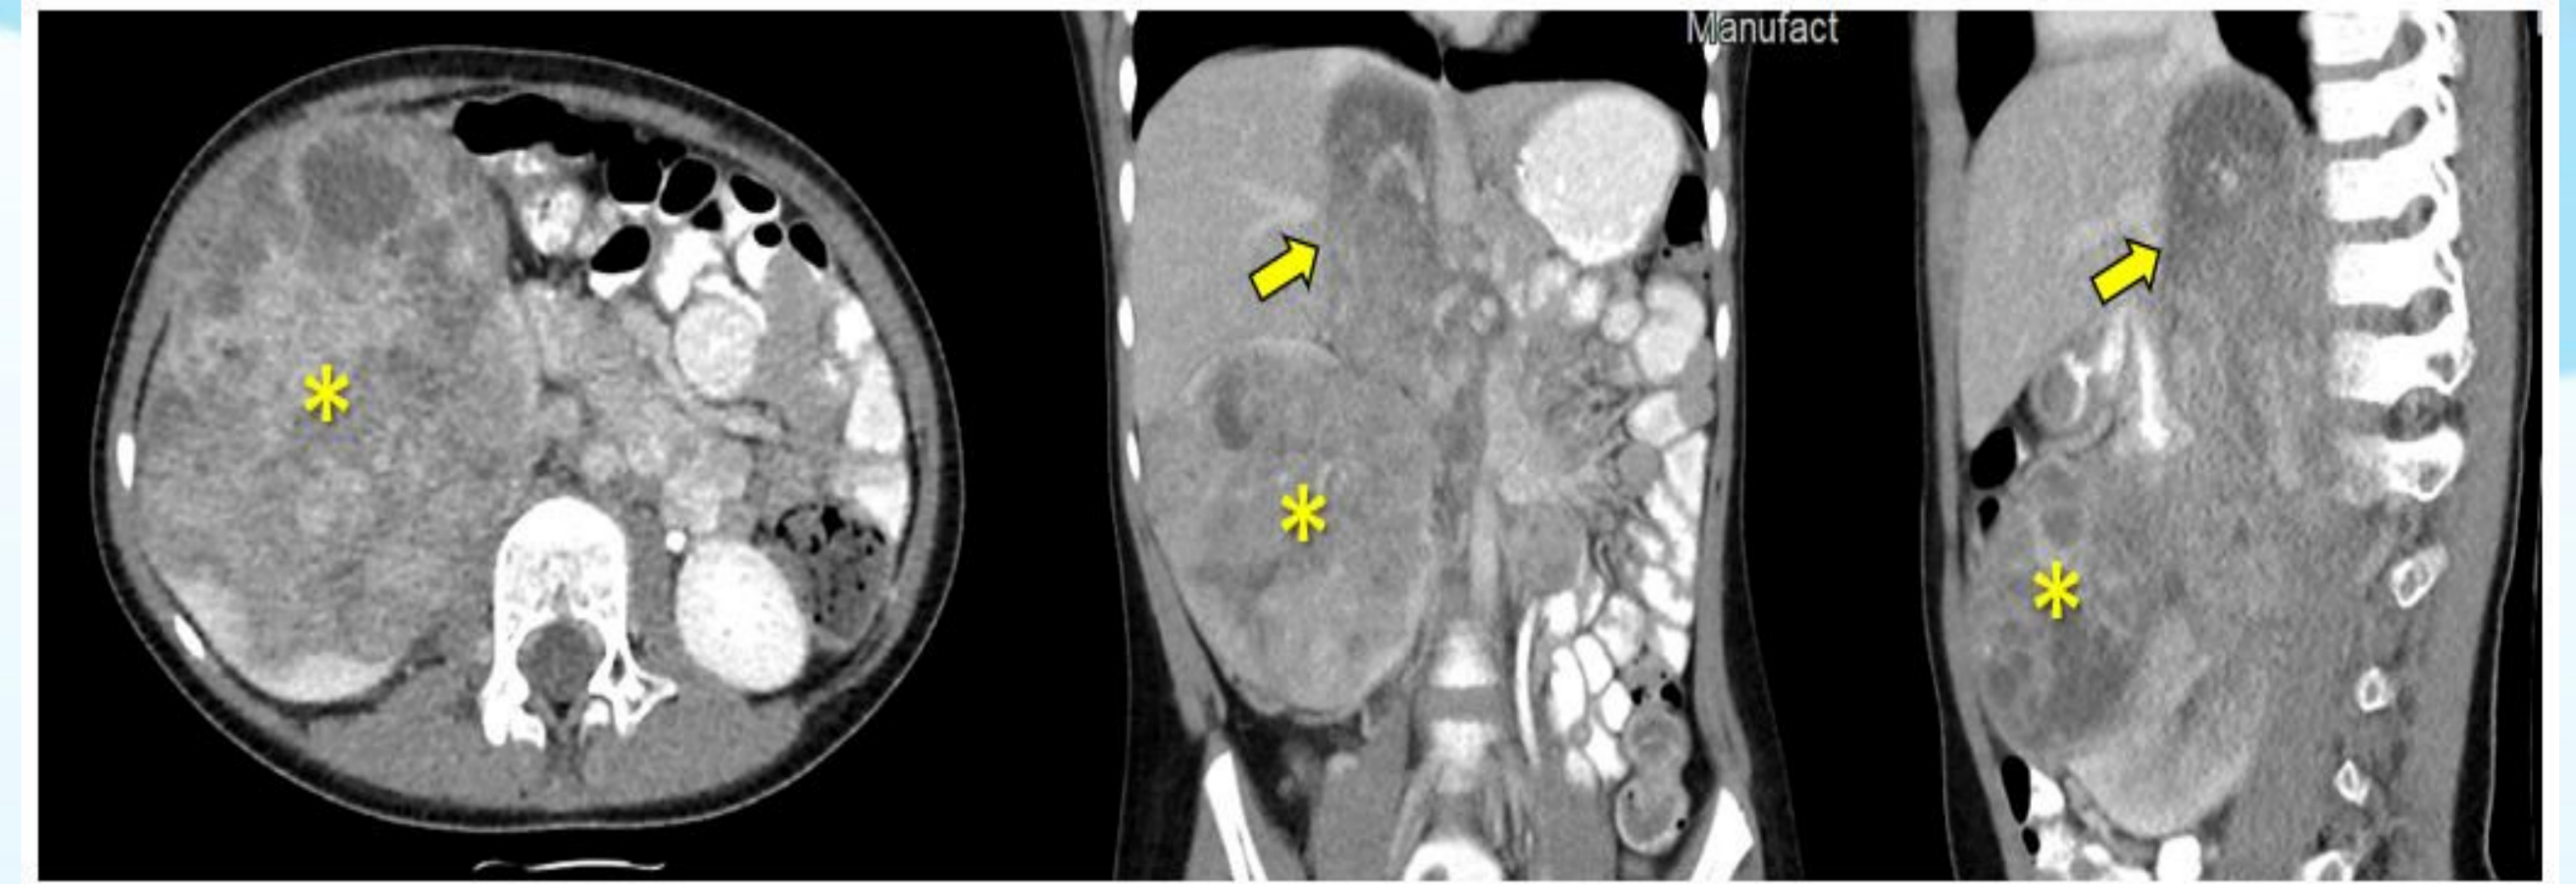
CT images at diagnosis showing huge tumour arising from the right kidney (asterisk) with intracaval tumour thrombus up to the suprahepatic level (arrow)
